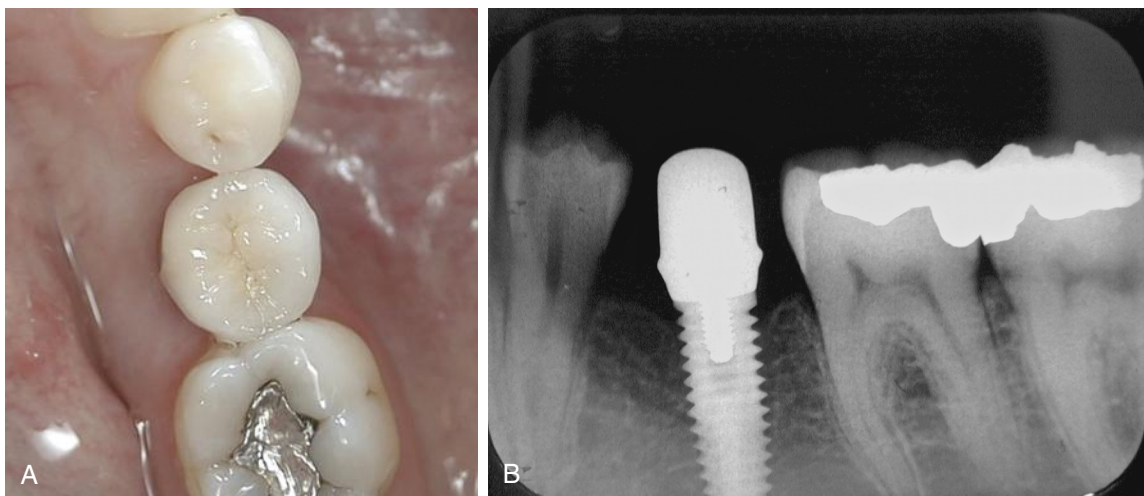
Single-tooth implant placed in the mandible. A, Clinical photograph after prosthetic replacement. B, Previous radiograph. Note that the implant had successfully undergone osseointegration of the titanium core and the prosthetic suprastructure could then be placed to replace a missing permanent mandibular second premolar due to partial anodontia. (A and B, From Newman MG, Takei HH, Klokkevold PR: *Carranza's Clinical periodontology*, ed 12, Philadelphia, 2015, Saunders/Elsevier.)
